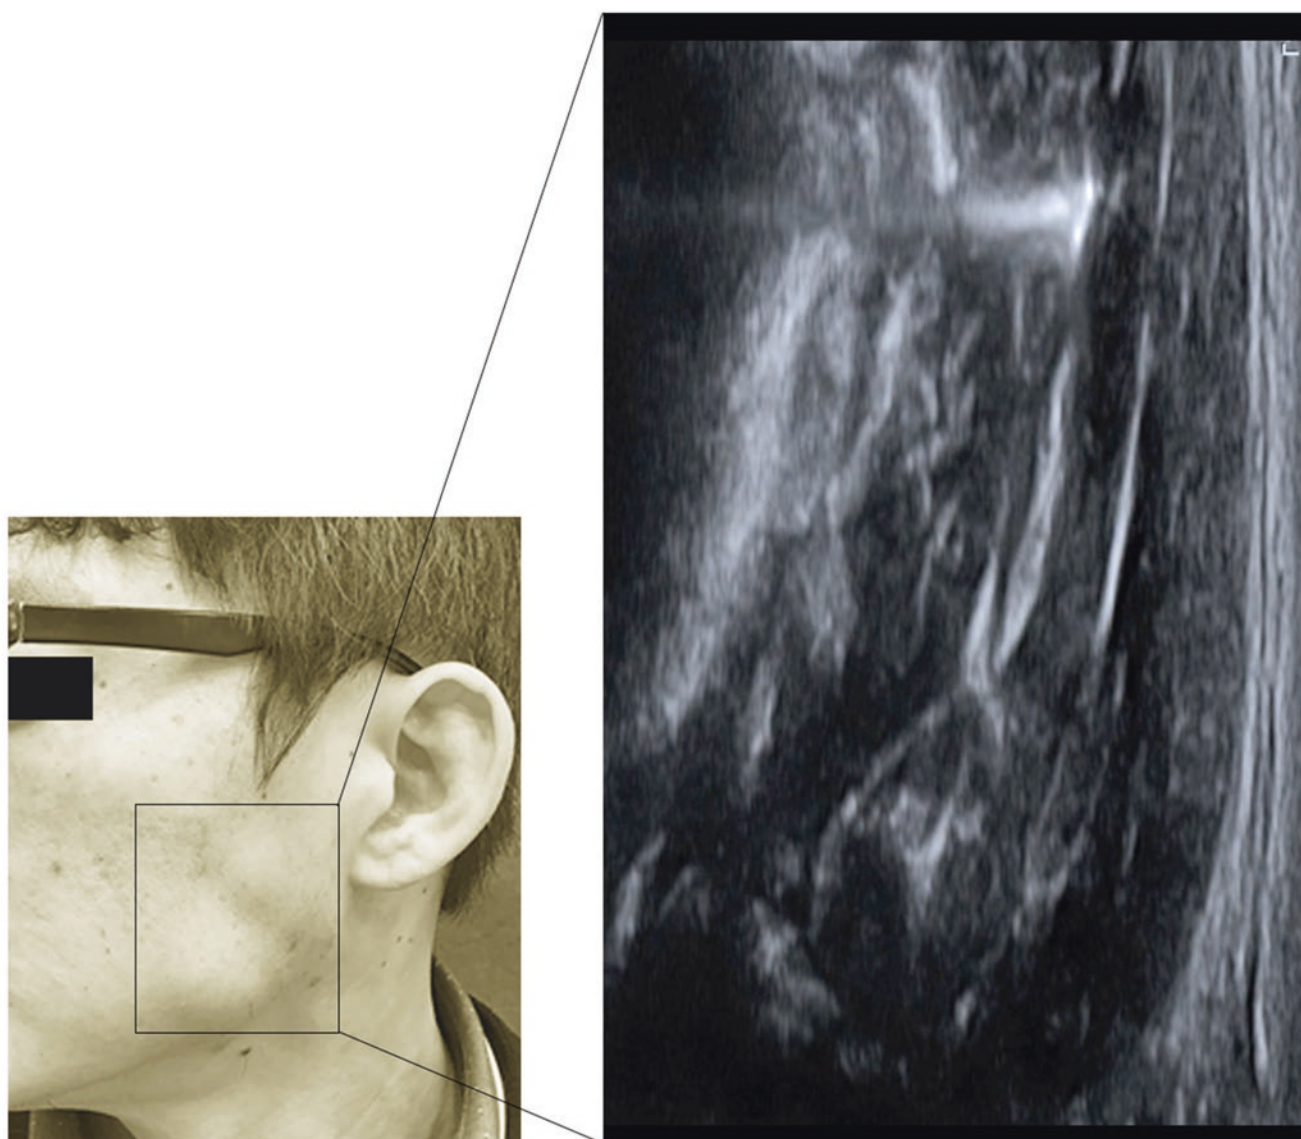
Ultrasonography of the mandibular angle (C4). (a) B mode (transverse view, 15 MHz by linear transducer) and (b) Doppler mode (transverse view, 15 MHz by linear transducer). (Published with kind permission of © Hee-Jin Kim 2020. All Rights Reserved)
